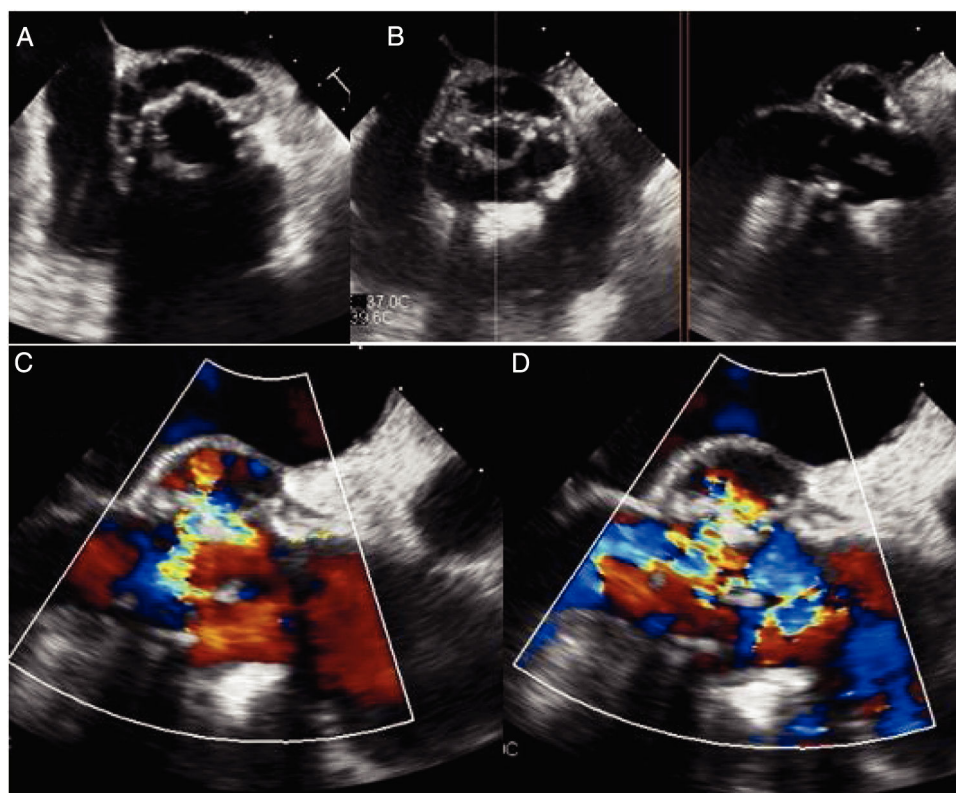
(A) Transesophageal echocardiography (longitudinal plane) showing a circumferential abscess 180° around the aortic prosthesis; (B) X plane imaging with transesophageal echocardiography showing the periprosthetic abscess. (C and D) Transesophageal echocardiography (horizontal plane) showing fistula from the ventricular outflow tract to the ascending aorta on a color Doppler map.
